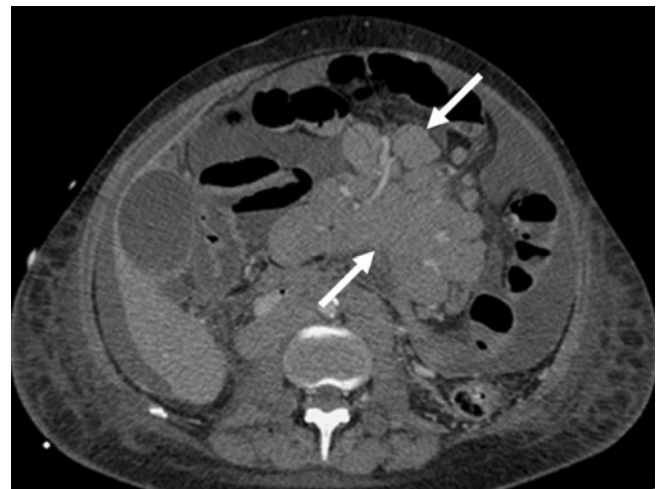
Axial CT in a patient with PTLD depicting ascites and conglomerate lymph nodal mass (*white arrow*) encasing the mesenteric vessels.
